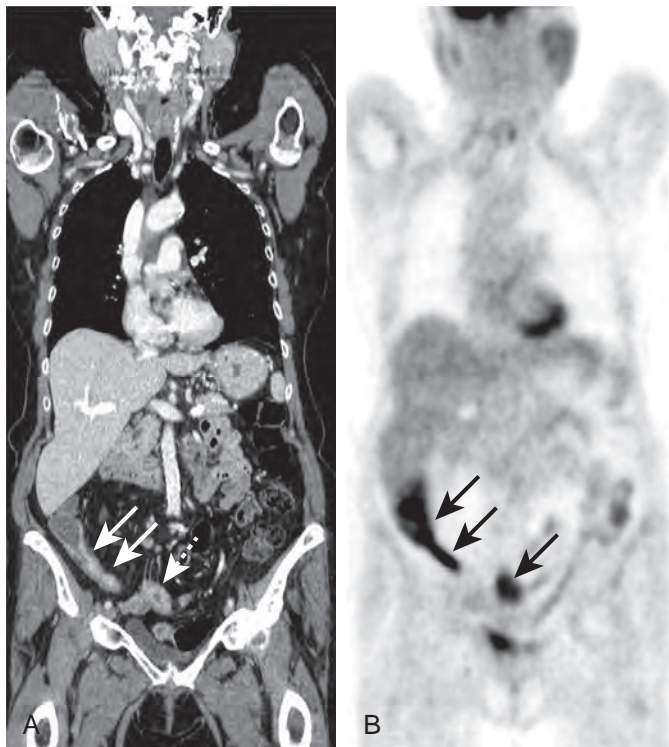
Crohn's disease. A. Coronal contrast-enhanced CT scan demonstrates bowel wall thickening and increased enhancement in the terminal ileum (solid arrows) and in the distal small bowel loops (dashed arrow). B. Corresponding whole-body MIP PET scan shows intense FDG uptake in the affected bowel loops (arrows).
